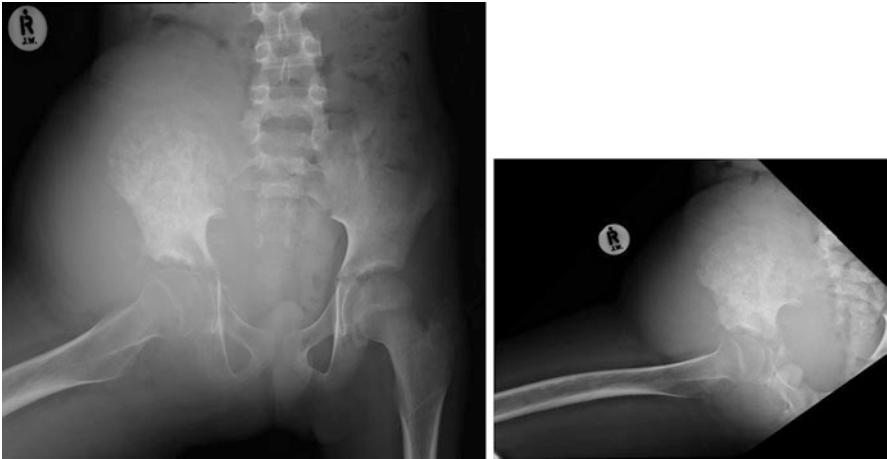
X-ray of right hip and pelvis
